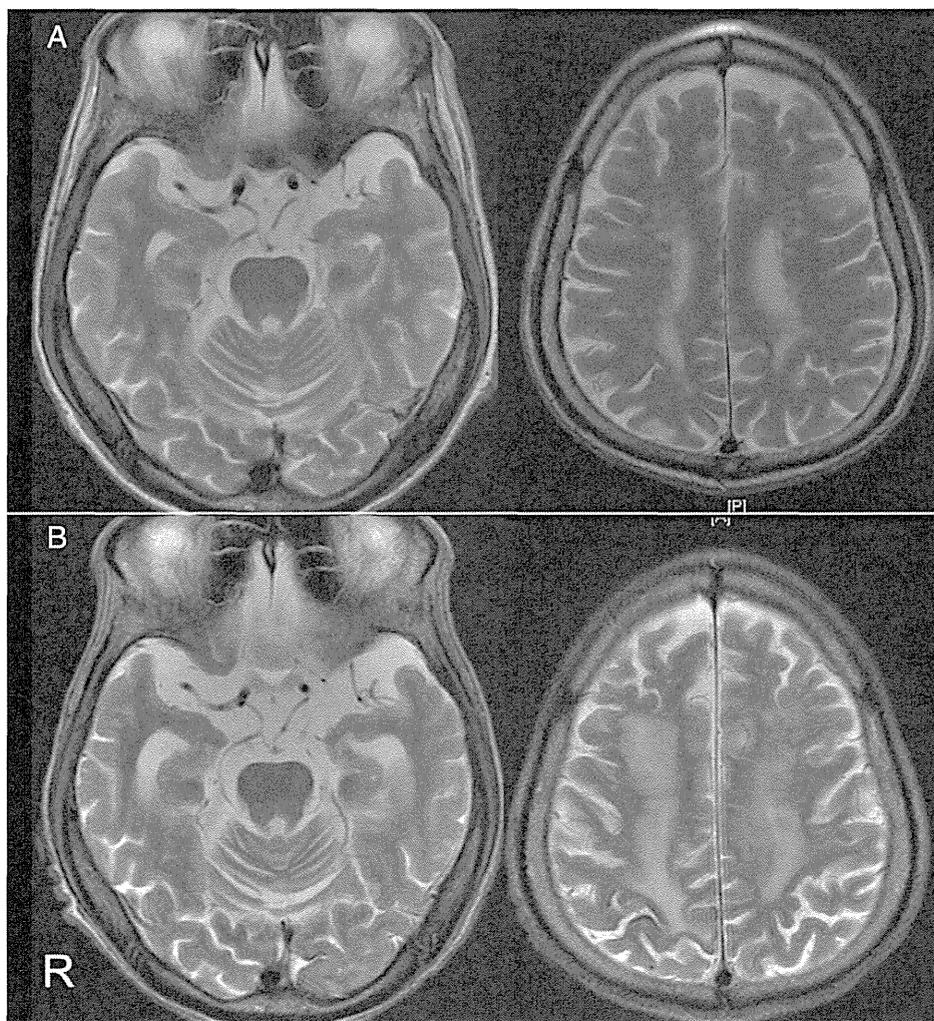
T2-weighted axial MRI of the patient at ages 73 (A) and 75 (B). Cerebellar anterior lobe shows atrophy. Medial temporal lobe shows progressive atrophy with white matter hyperintensities.
